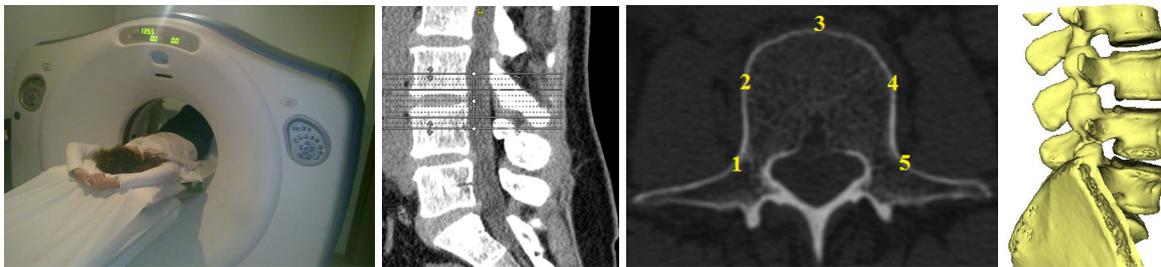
CT obtained in medical clinical to measure the cortical lumbar vertebra (L2-L5).
